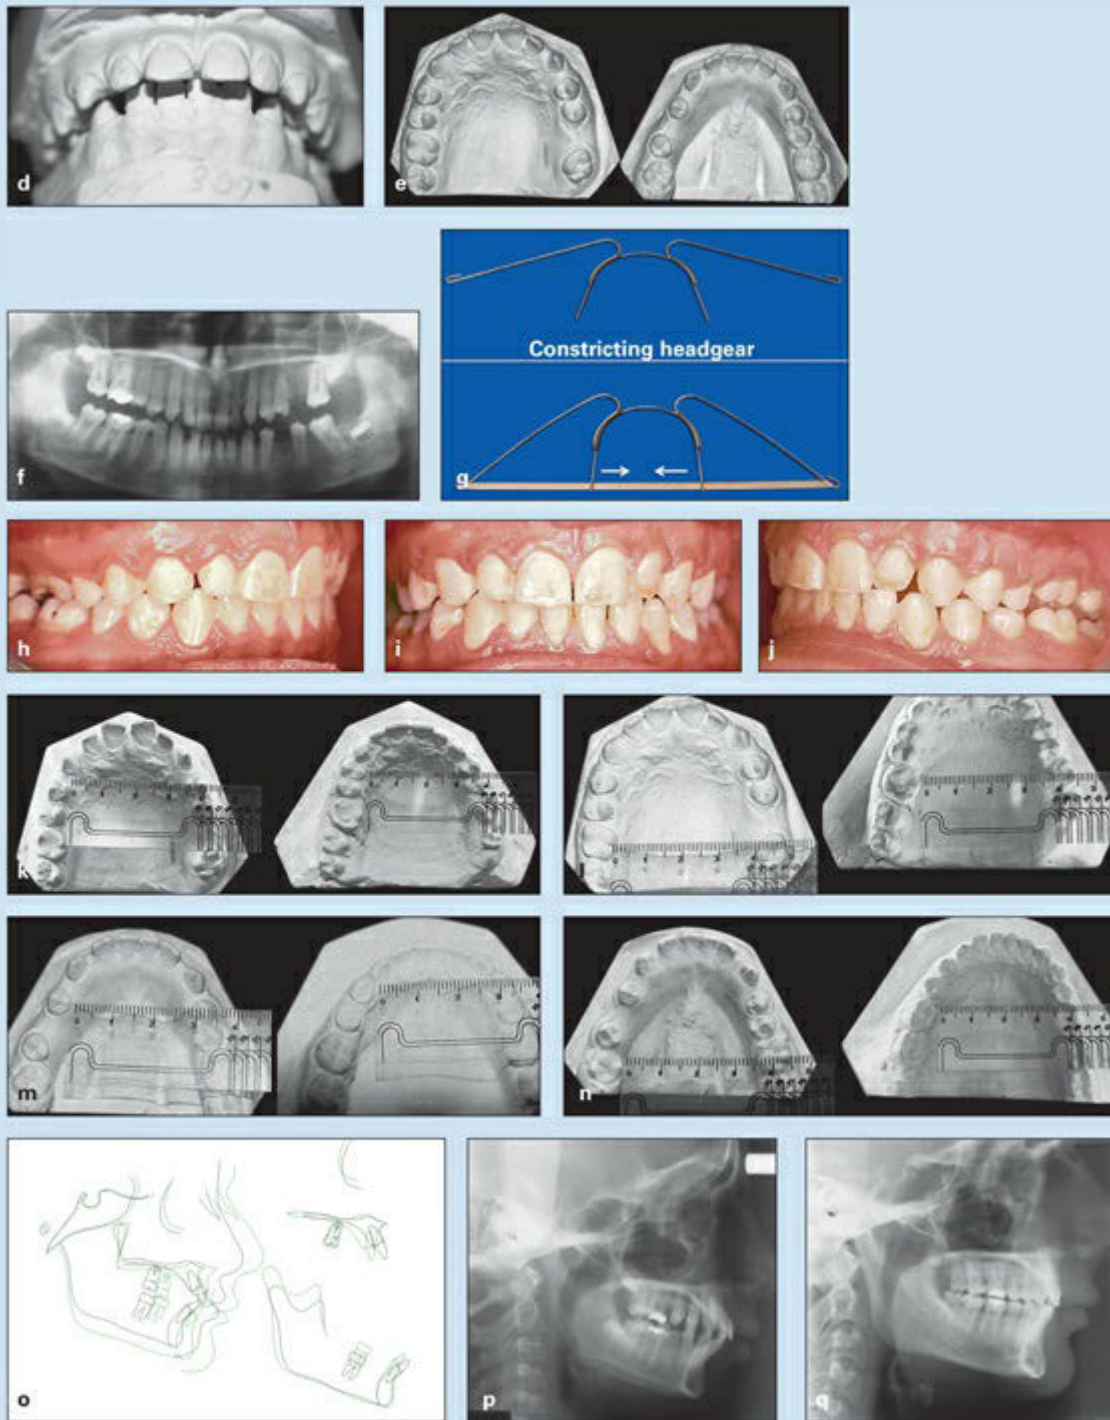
(cont) (d and e) Pretreatment casts. (f) Pretreatment panoramic radiograph. (g) Design of the facebow used for constriction and distalization of the maxillary molars. (arrows) Direction of movement. (h to j) Posttreatment occlusion. (k) Changes in maxillary premolar width. (l) Changes in maxillary molar width. (m) Changes in mandibular premolar width. (n) No changes in mandibular molar width. (o) Superimposition of pretreatment (black) and posttreatment (green) tracings. (p) Pretreatment cephalometric radiograph. (q) Posttreatment cephalometric radiograph.
